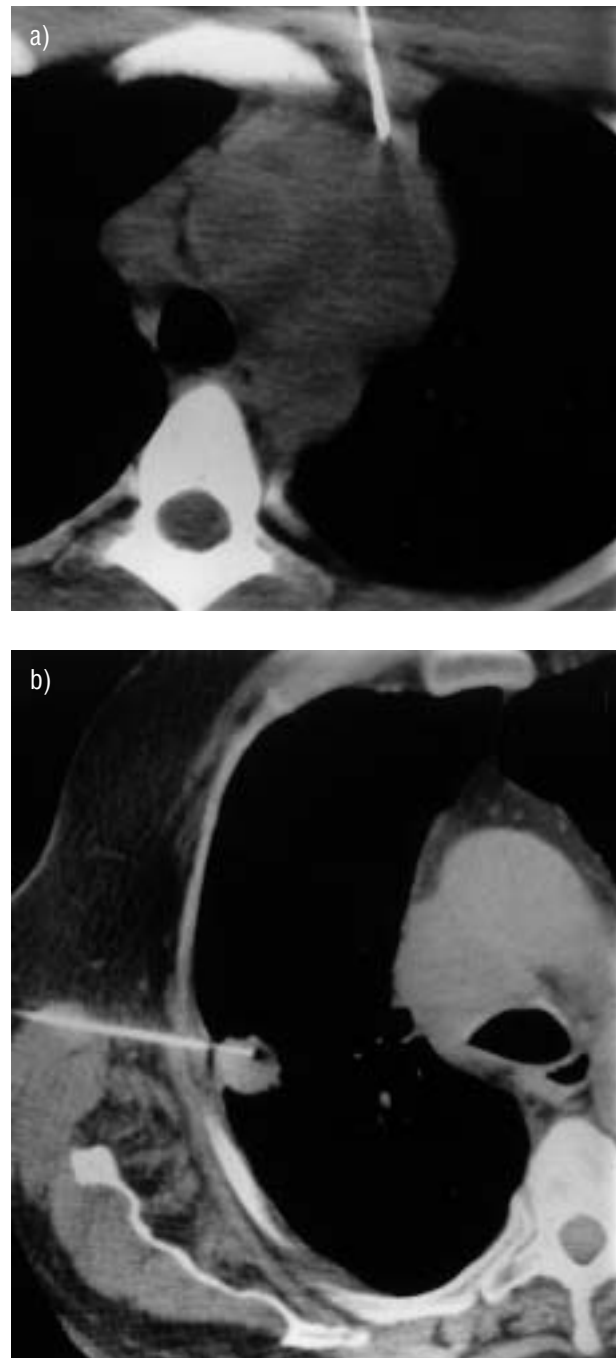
Versatility of transthoracic needle biopsy with needle tip in a) mediastinal mass (note safe approach) and b) peripheral solitary nodule.
